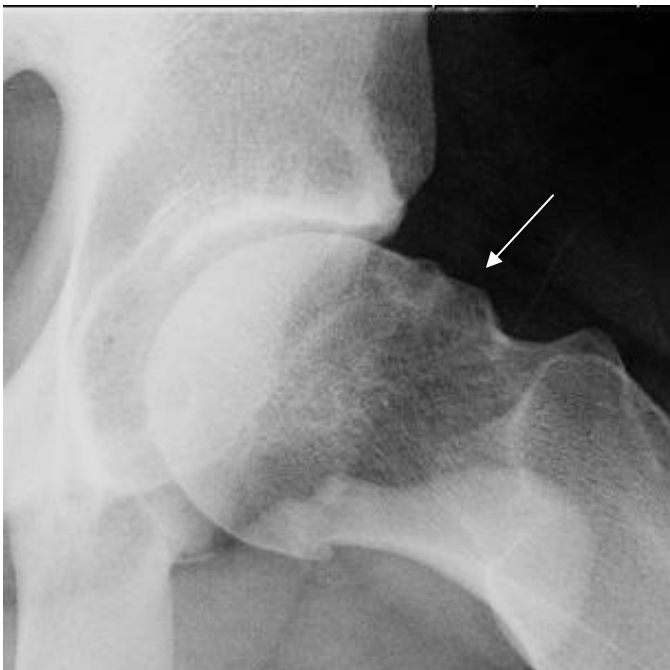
Frog leg lateral left hip radiograph nicely shows the abnormal convexity of the anterolateral femoral head-neck junction (white arrow). Subchondral sclerosis and joint space loss are well seen on this view. Also note the cystic changes at the femoral head-neck junction.
